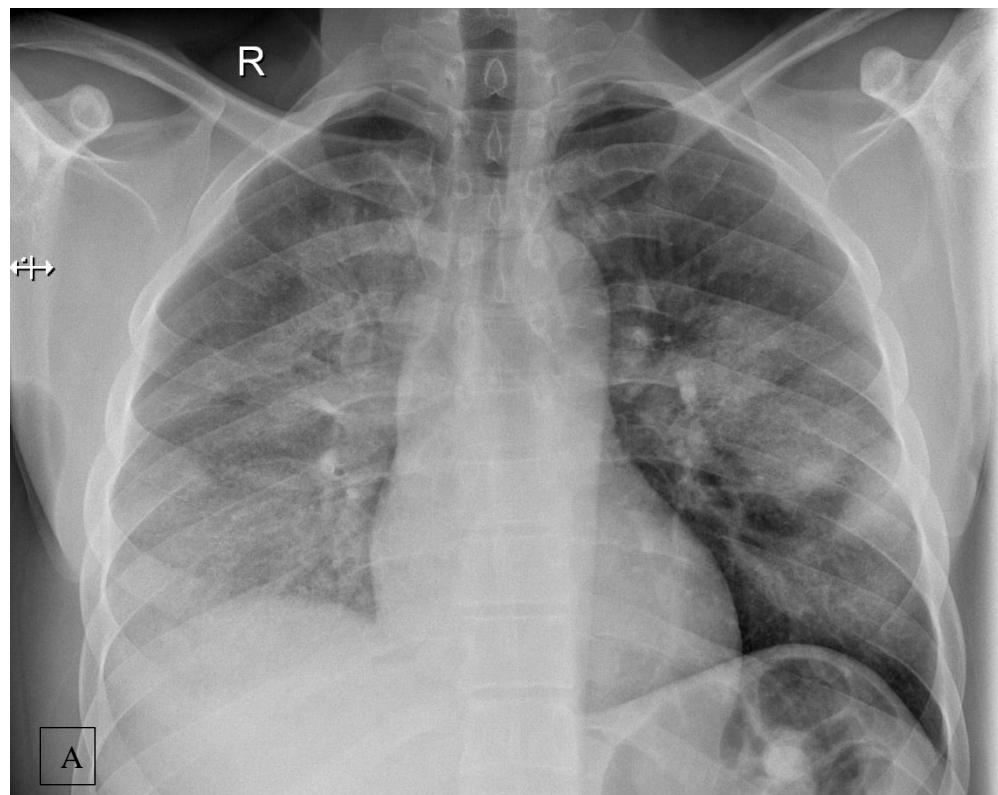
Chest radiograph were divided into 12 areas/zones for the assessment of the degree of involvement. 3 horizontal zones, upper, middle and lower divided by 2 vertical zones; central and peripheral zones.
